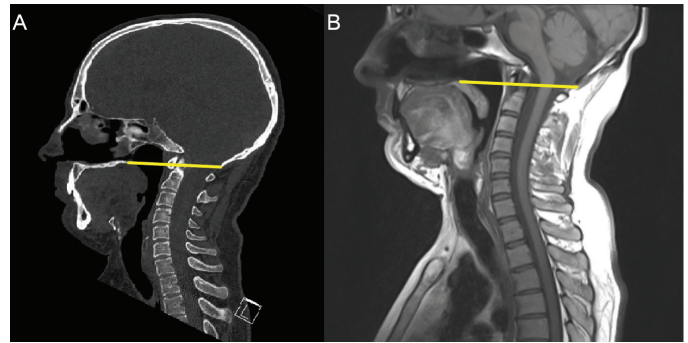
Patient's (A) cranio-cervical CT and (B) cranio-cervical MRI T1 weighted sagittal section. It can easily be seen that the top of C1 is about 0.6 cm above Chamberlain's line (yellow line)
